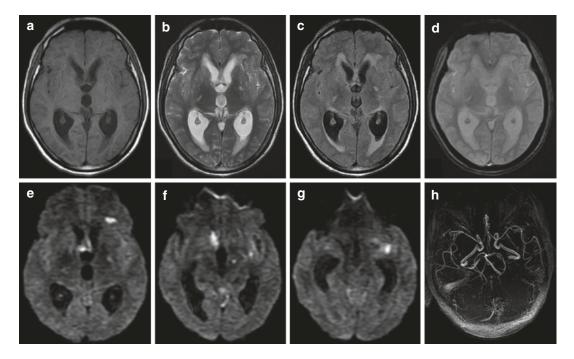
MRI of the brain in a patient with TBM presenting with hydrocephalus (a-d) with multiple small infarcts (e-g) and thinning of the distal vasculature (h)
